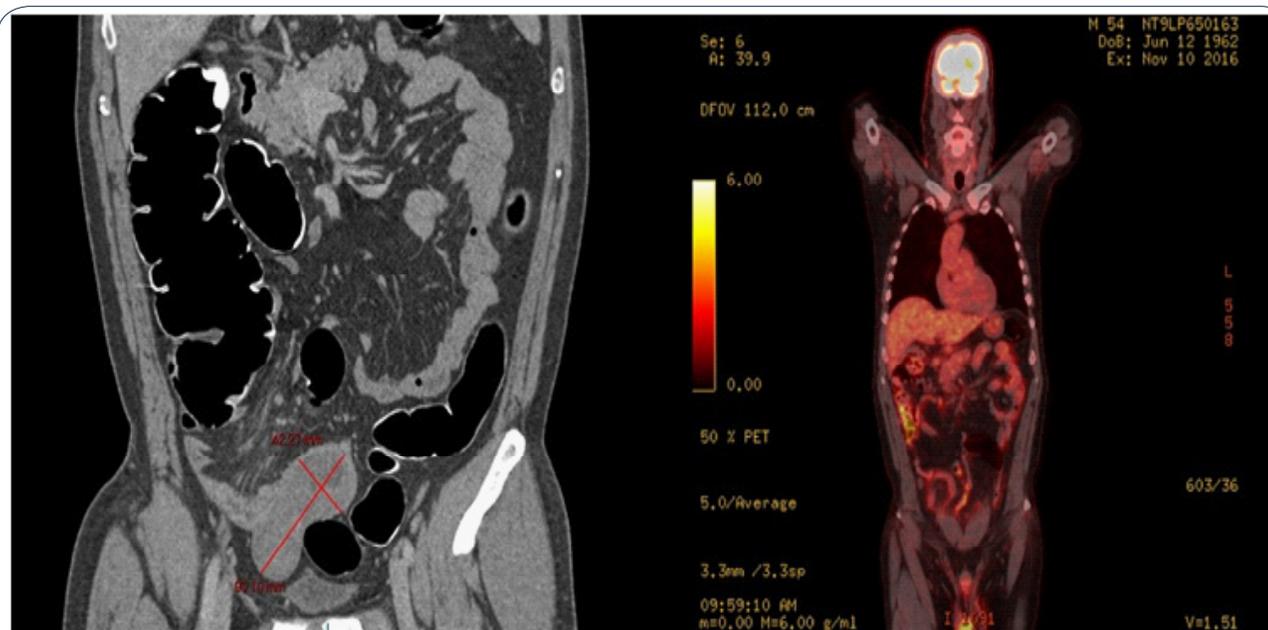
A comparison of the radiological finding of this case. Left is CT colon clearly showing the tumour and volvulus and to the right the PET CT that showed no "hot spots".
